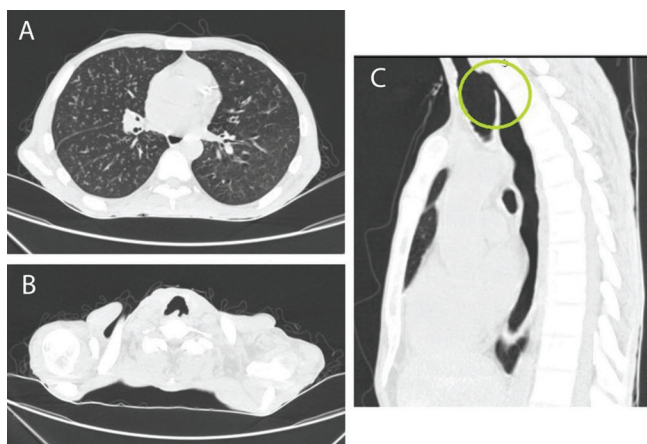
(A) HRCT Chest of the patient showing B/L ill defined centrilobular nodules with VY branching pattern (Rt>Lt). (B) HRCT Chest showing a fistula arising from the trachea. (C) Sagittal cuts on HRCT Chest showing the TEF (Marked in green circle).
